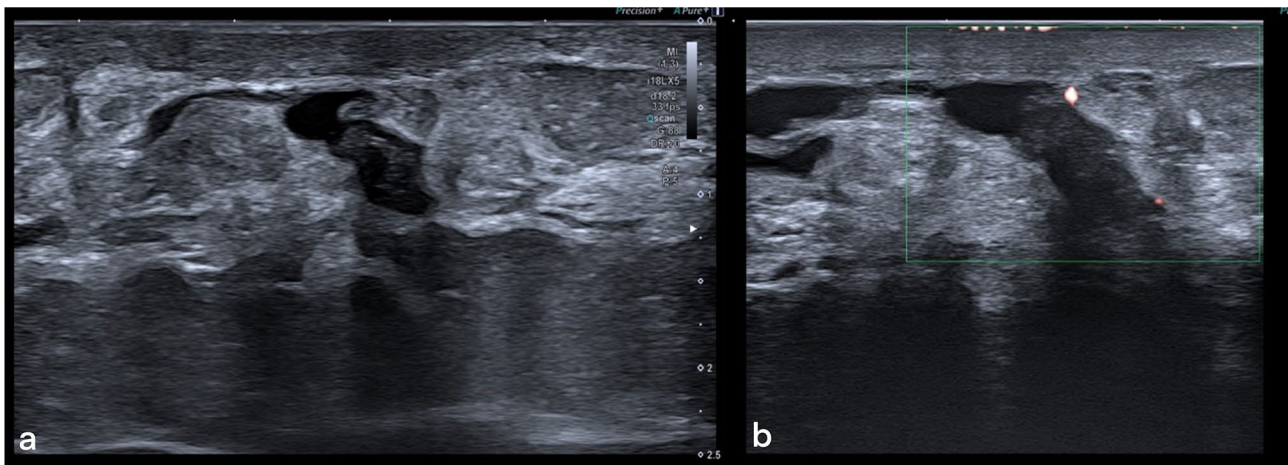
a Ultrasound shows skin thickening and retroareolar ductal ectasia with echogenic contents and increased periductal Doppler signal (b)
